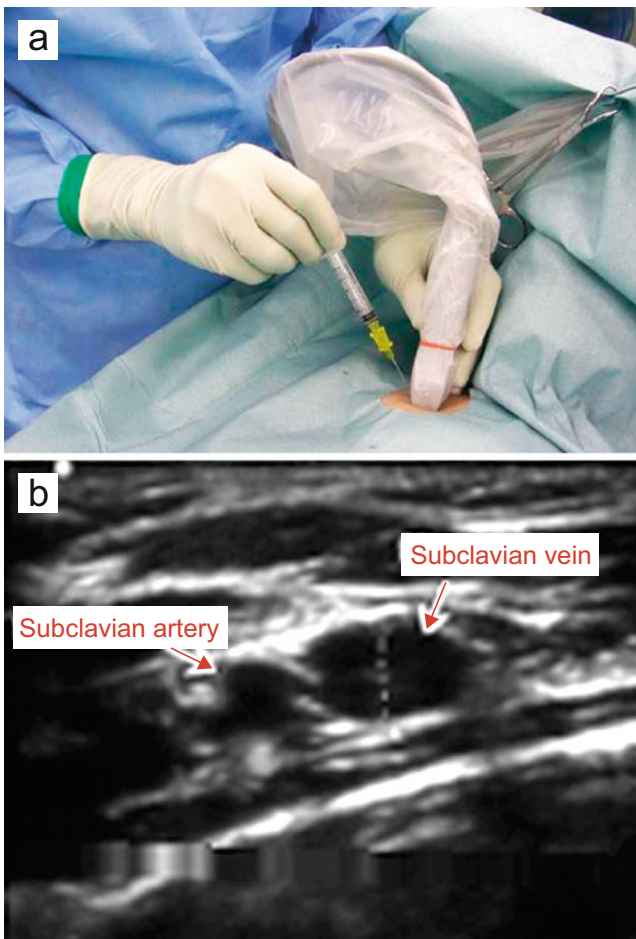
Locating the subclavian vein under echocardiographic guidance. (a) Subclavian puncture under echocardiographic guidance. (b) Subclavian vessels on echocardiography. When pressed by an echocardiographic probe, the vein is flattened but the lumen of the artery is maintained and beats can be observed
